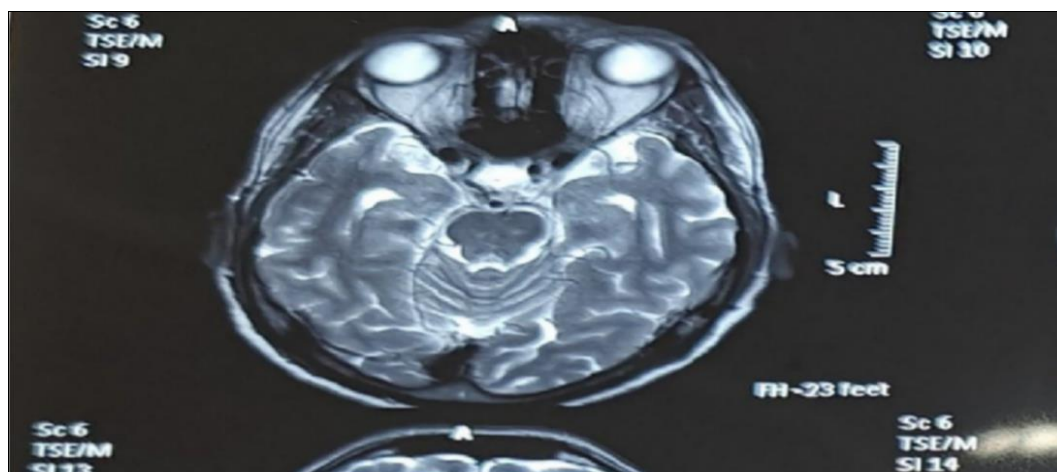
T₂-weighted fast spin-echo axial MRI section through the aqueduct and upper fourth ventricle showing CSF flow void, which is specific for hyperdynamic flow.
